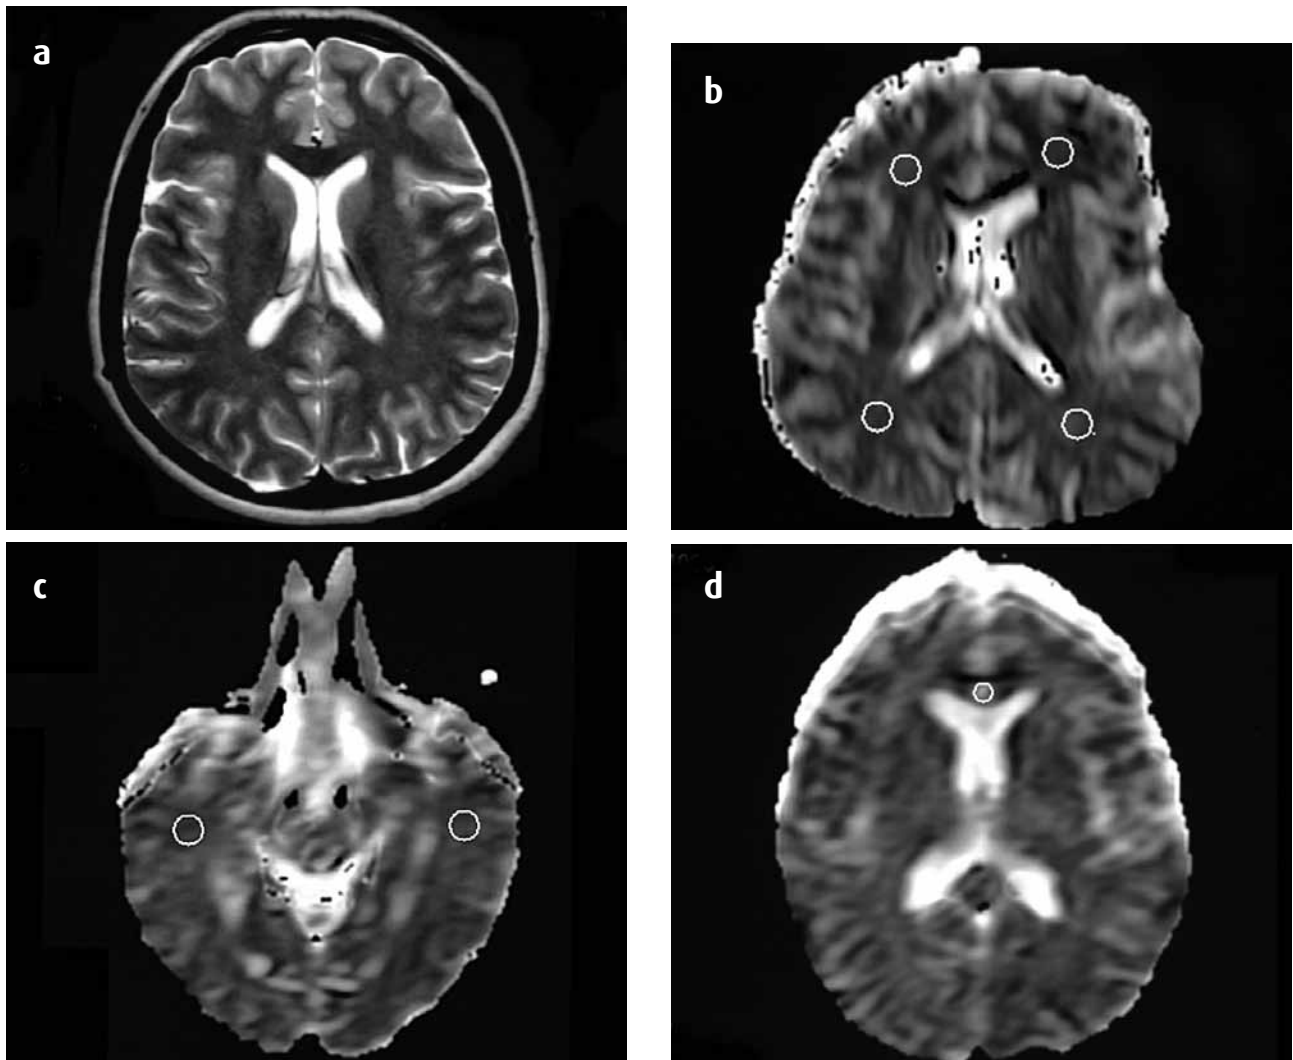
Axial T2-weighted image shows white matter areas that do not include focal hyperintensities (a). Axial ADC maps showing determined measurement areas (ROIs) on bilateral frontal and occipital lobes (b), temporal lobes (c), and the genu of the corpus callosum (d).
